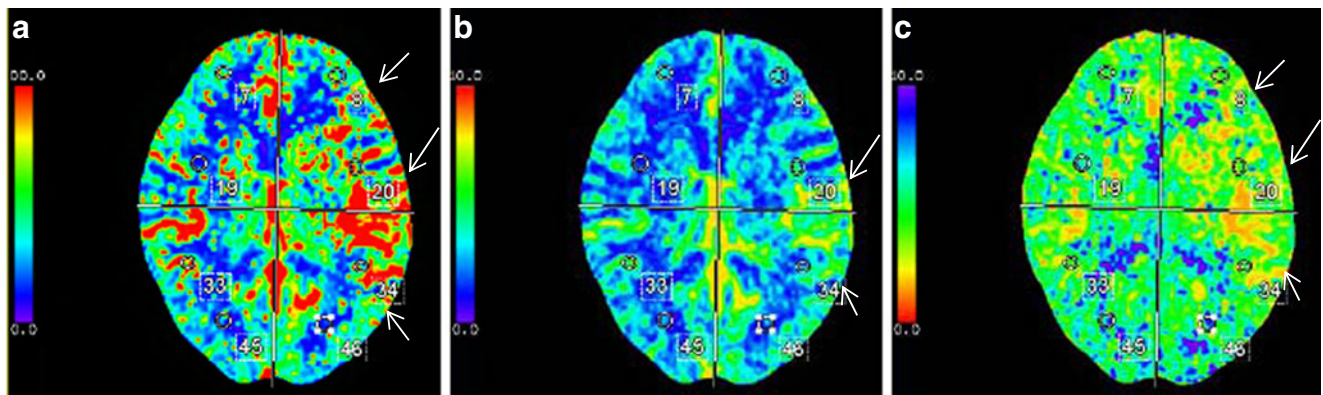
CT perfusion during headache. a CBF, b CBV, and c MTT maps reveal abnormally increased CBF, increased CBV, and decreased MTT throughout the entire left cerebral hemisphere, respectively; findings are consistent with hyperperfusion
